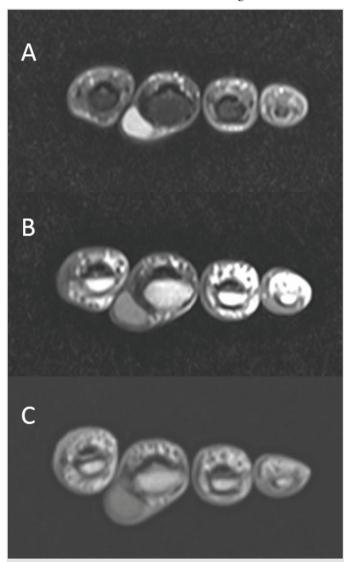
a-c. Epidermal inclusion cyst in a 45-year-old male presenting with a lump over the third proximal interphalangeal joint. Axial PD-weighted fat-saturated (a) MR image demonstrates a smooth, well-demarcated subcutaneous hyperintense lesion. Axial precontrast (b) and postcontrast (c) T1-weighted MR images demonstrate a mildly hyperintense mass lesion due to high lipid content with no contrast enhancement
